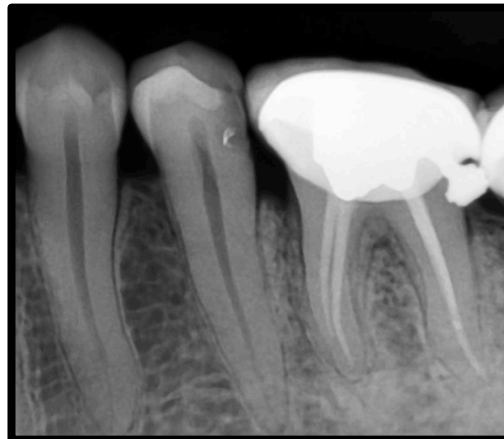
INTRA ORAL PERIAPICAL RADIOGRAPH - 45
